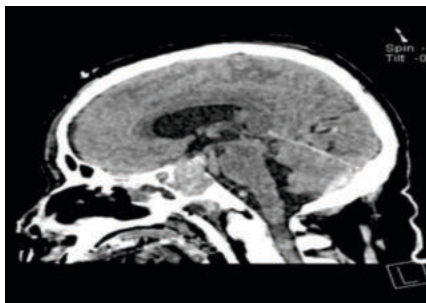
MRI showing Pituitary macroadenoma
